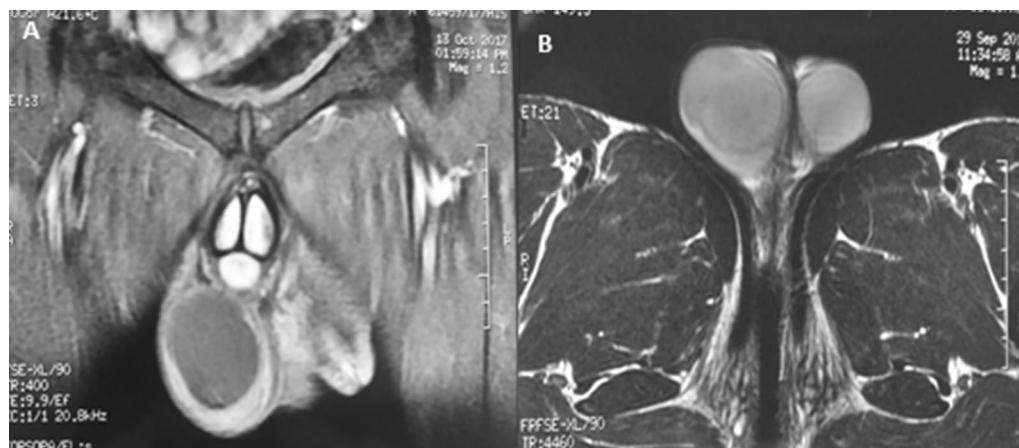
Coronal (a) and axial (b) section of magnetic resonance imaging objectifying an intra-testicular cystic mass
